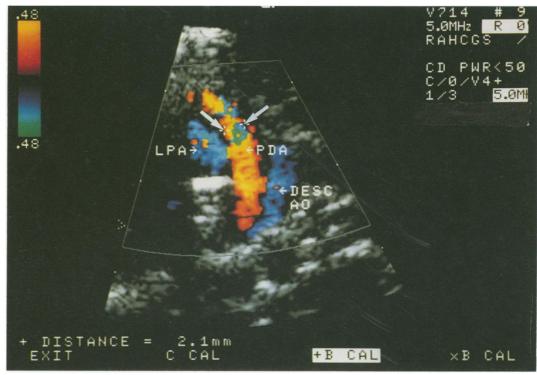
Measurement of colour flow Doppler of ductal shunt (orange). The calipers (marked by arrows) are positioned at the site of maximum constriction. In this case the minimum diameter was $2 \cdot 1$ mm near the pulmonary end of the ductus. Flow in the left pulmonary artery (LPA) and descending aorta (Desc Ao) is shown in blue.
